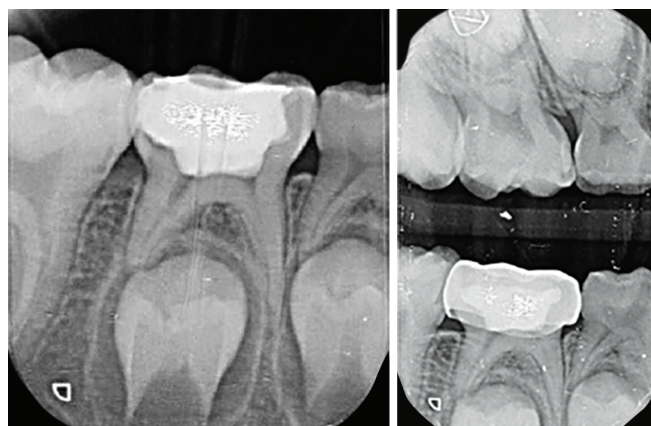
Pre- and postoperative radiograph
